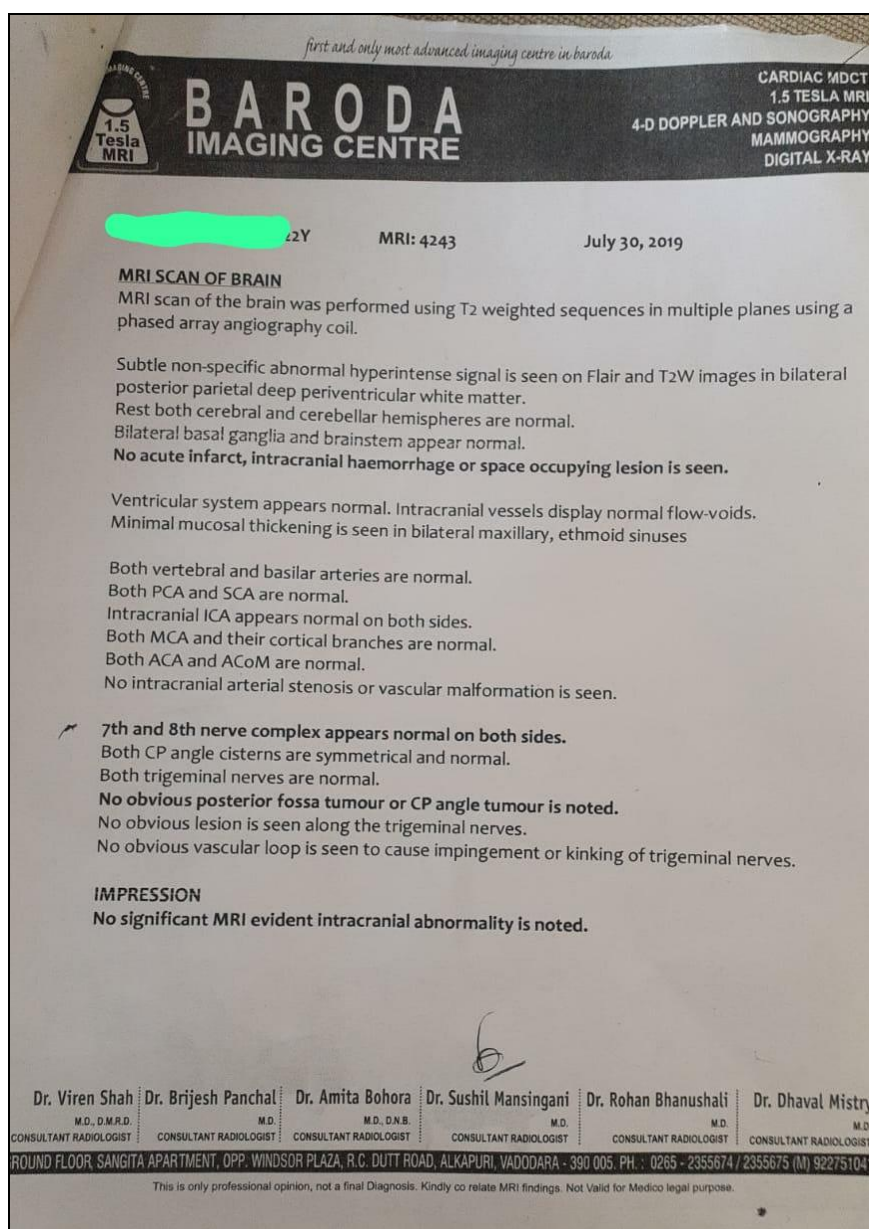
Show the MRI Scan of brain
